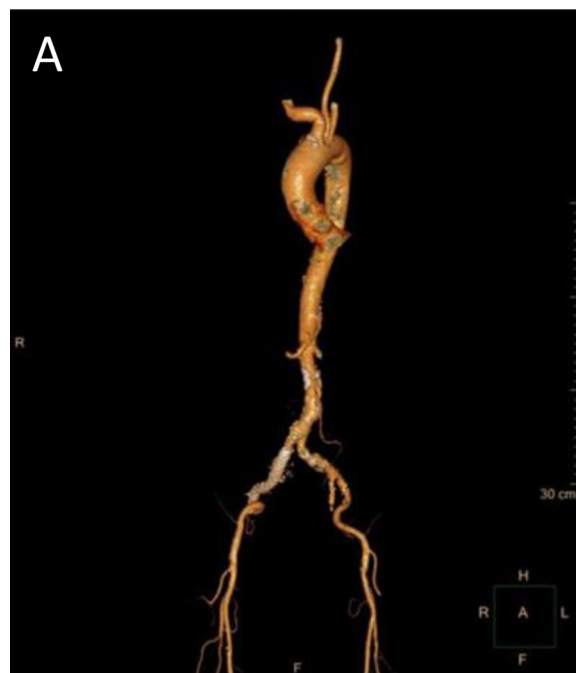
After two endovascular operations, No iliac aneurysm, right iliac vein, and inferior vena cava are found on aortic CTA.
